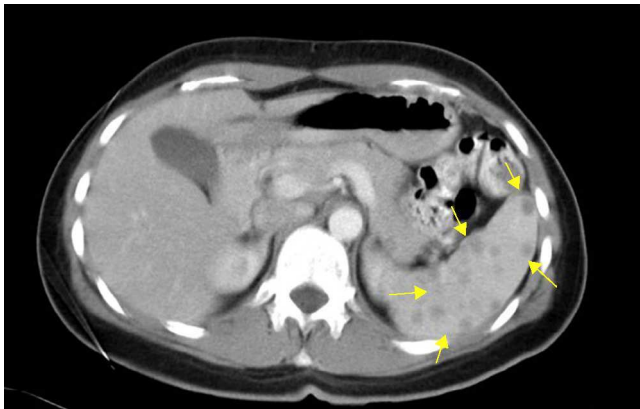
Abdominal contrast CT scan, which shows multiple spleen lesions with no contrast uptake (arrows).
